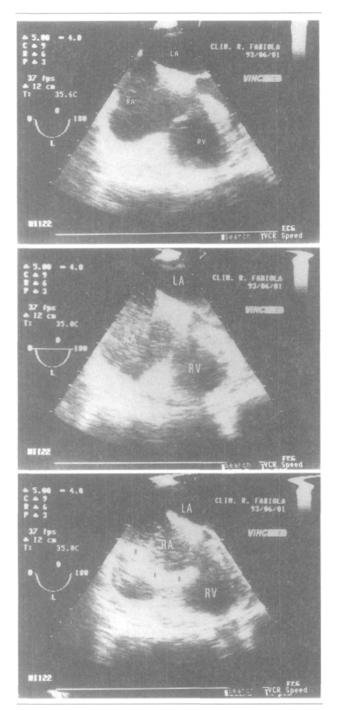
Four-chamber transocsophageal echocardiographic views showing embolism during total hip arthroplasty: (A) control view, (B) "snow flurry" in the right atrium, (C) small and large emboli in the right atrium. RA = right atrium; RV = right ventricle; LA = left atrium; SF = snow flurry; E = embolus.
